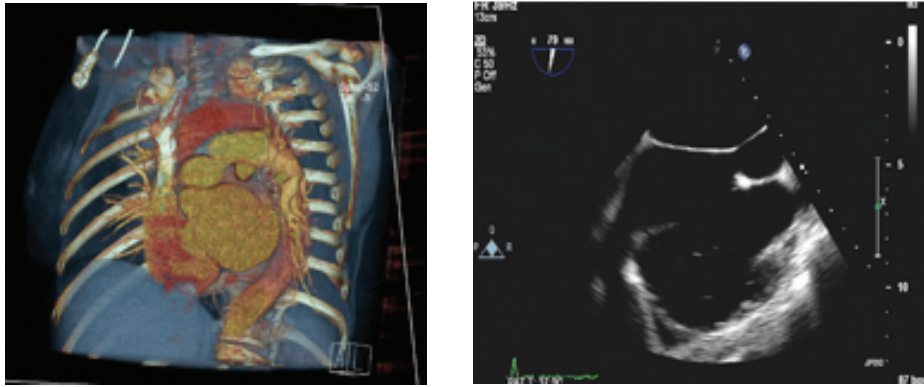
Three-dimensional reconstruction image (A) from a cardiac computed tomography examination (B) suggestive of cor triatriatum with an associated atrial septal defect and normal pulmonary venous connections.
